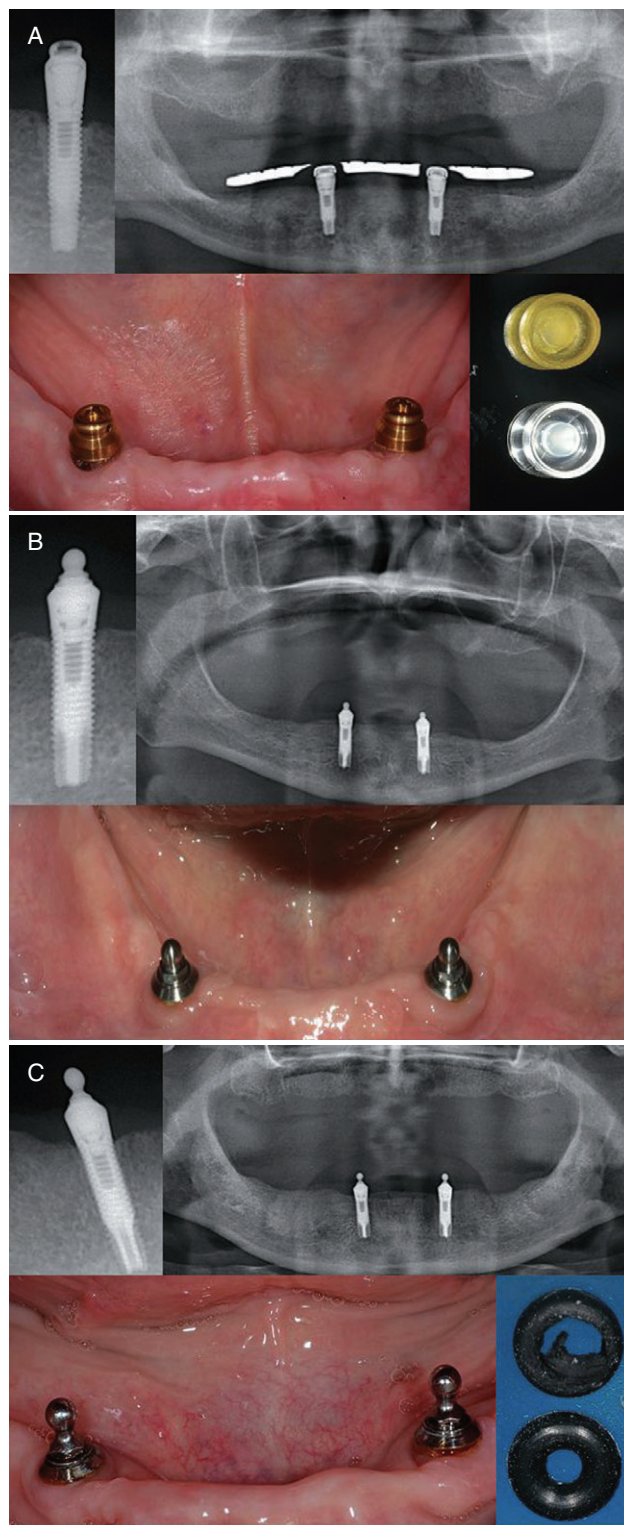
Radiologic and clinical views on the different abutment systems: (A) Locator (panoramic X-ray with prosthesis) with attachment matrices (below: new; above: after clinical use), (B) Dal-Ro, and (C) TG-O-Ring with attachment matrices (below: new; above: after clinical use).
